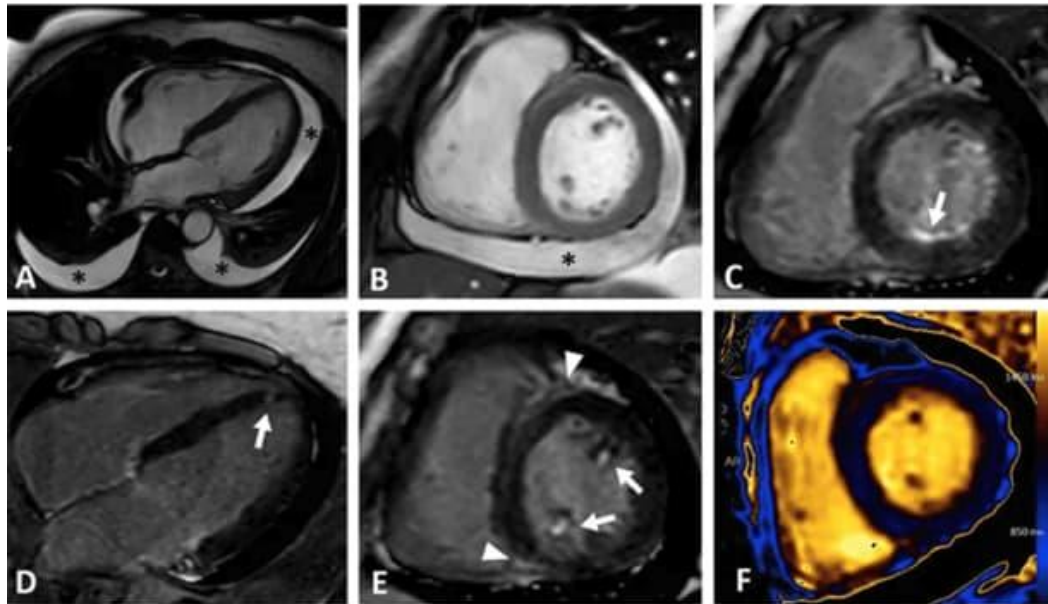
Cardiac MRI demonstrating myocardial fibrosis and late gadolinium enhancement in systemic sclerosis-associated myocarditis. Reproduced from Vitale et al. (2025) under CC BY 4.0 license¹³.
